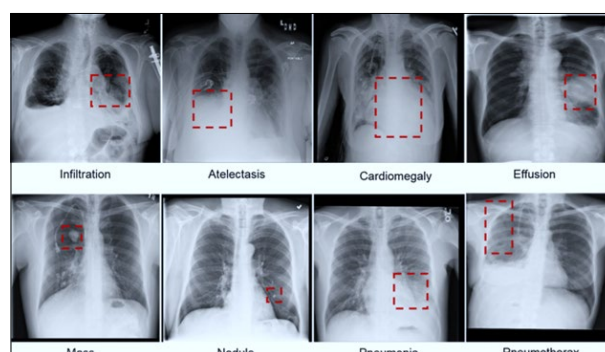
Conventional X-ray images showing the disease that can be occurred due to Pneumonia or after the Treatment of Neumonia. The red mark represents the site of the Pathology in Lungs in both the right and left side
